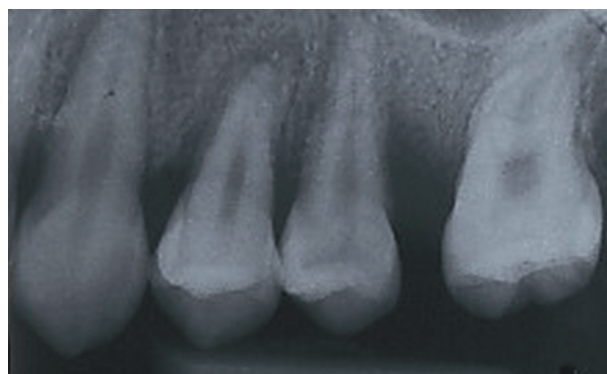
The radiography of the tooth 2.5 shows distal bone loss, and a widened periodontal space.
